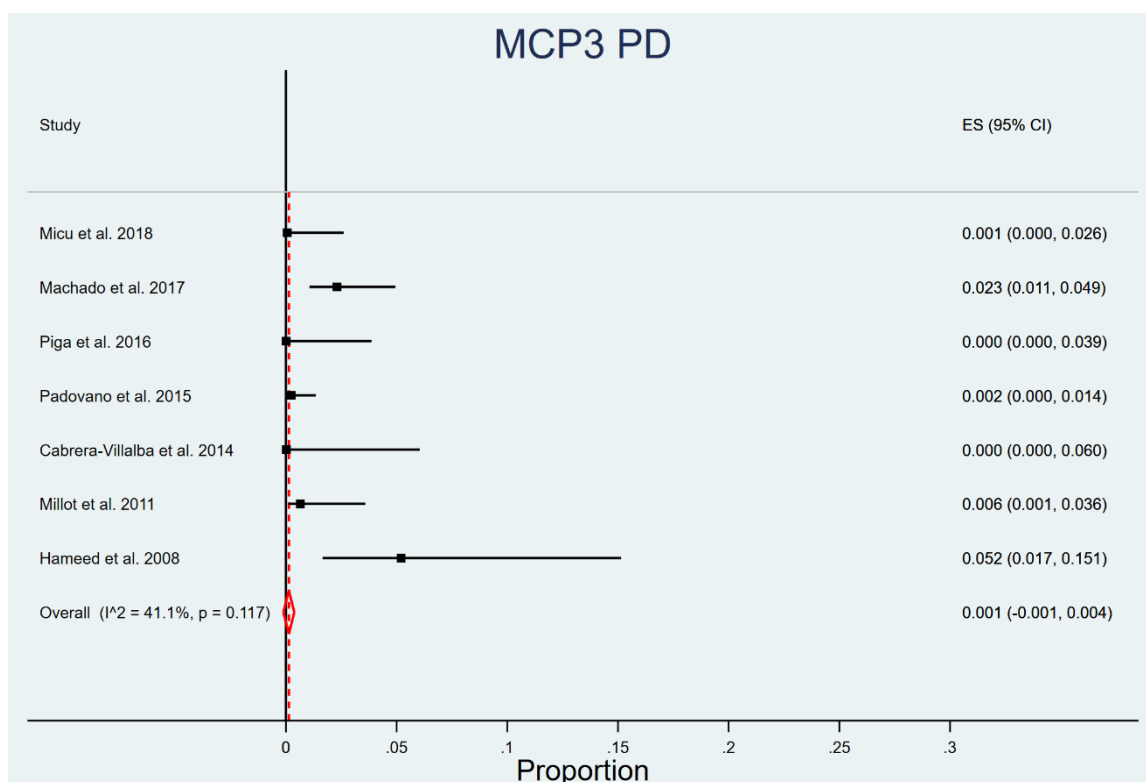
Forest plot showing proportion of healthy subjects with grade ≥ 1 power Doppler in third metacarpophalangeal joint
